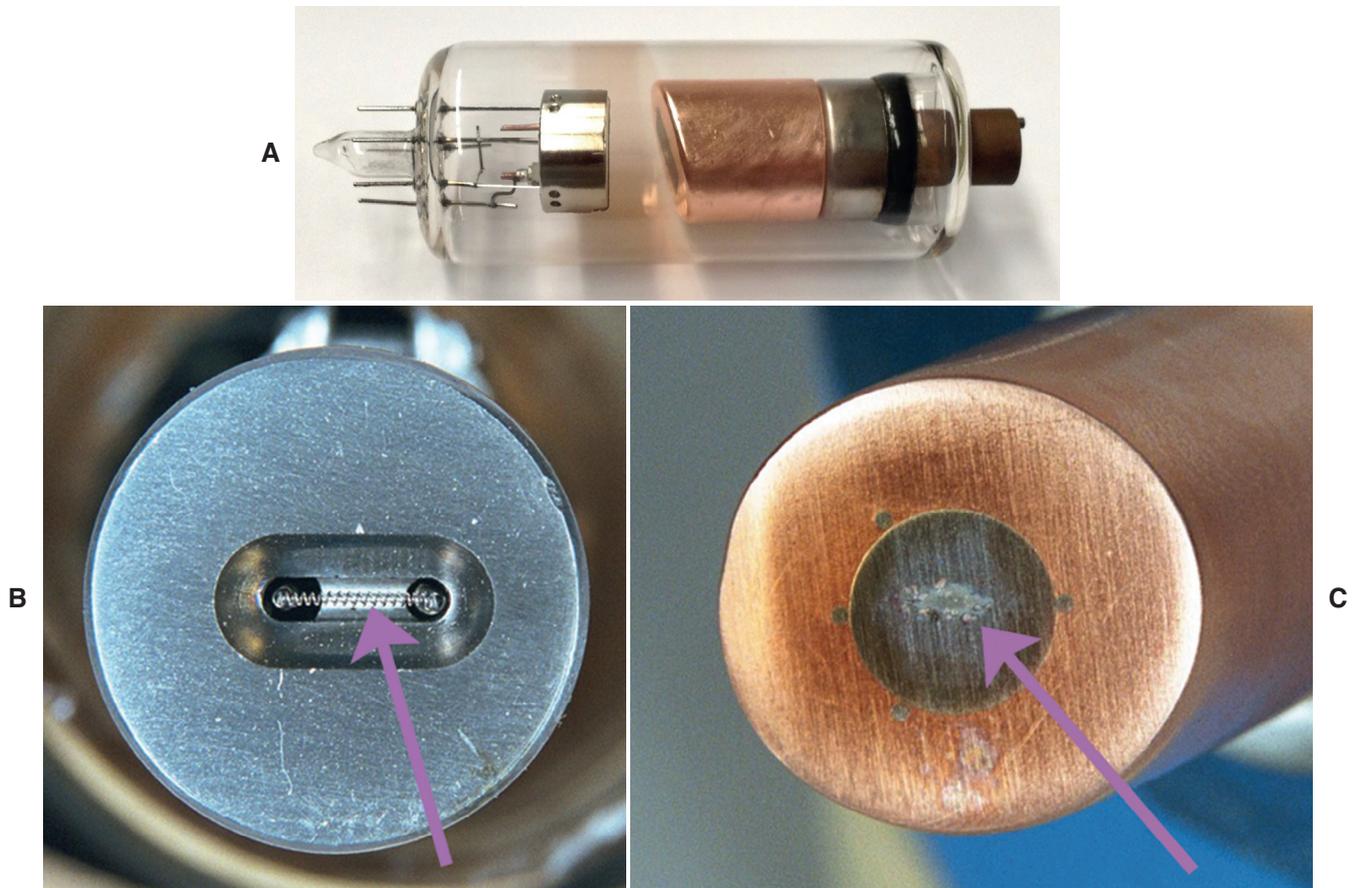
(A) Dental stationary x-ray tube with cathode on left and copper anode on right. (B) Focusing cup containing a filament (arrow) in the cathode. (C) Copper anode with tungsten inset. Note the elongated actual focal spot area (arrow) on the tungsten target of the anode. (B and C, Courtesy John DeArmond, Tellico Plains, TN.)
